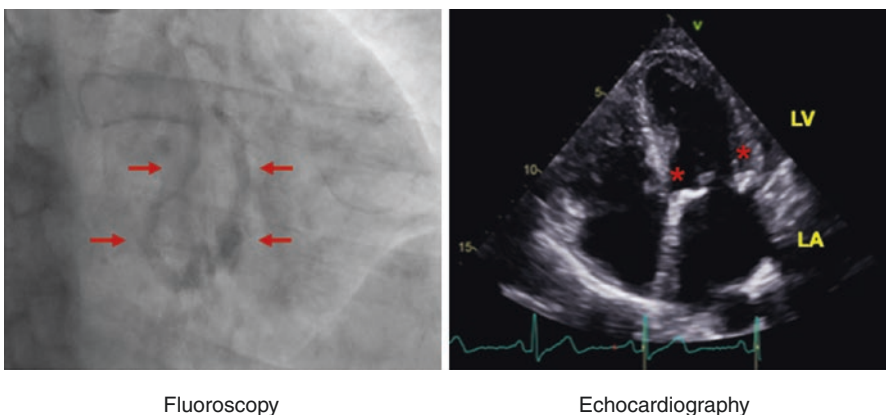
Mitral annular calcification. Calcification of the mitral annulus occurs frequently and is often seen by fluoroscopy at the time of routine cardiac catheterization (red arrows, left). Mitral annular calcification is also seen on echocardiography. Calcification appears as bright white areas at the edges of the mitral valve leaflets (below red asterisks). LA left atrium, LV left ventricle
